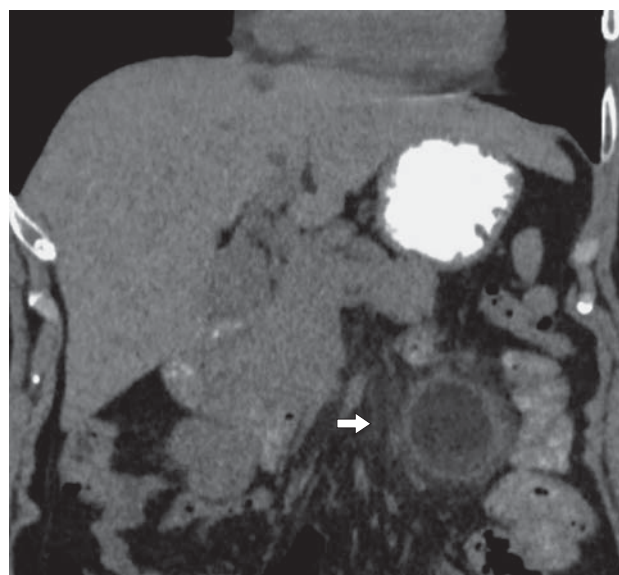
CT scan of the abdomen, coronal section. Encapsulated formation of fat density in the region of the root of the mesentery of the small intestine (arrow).
